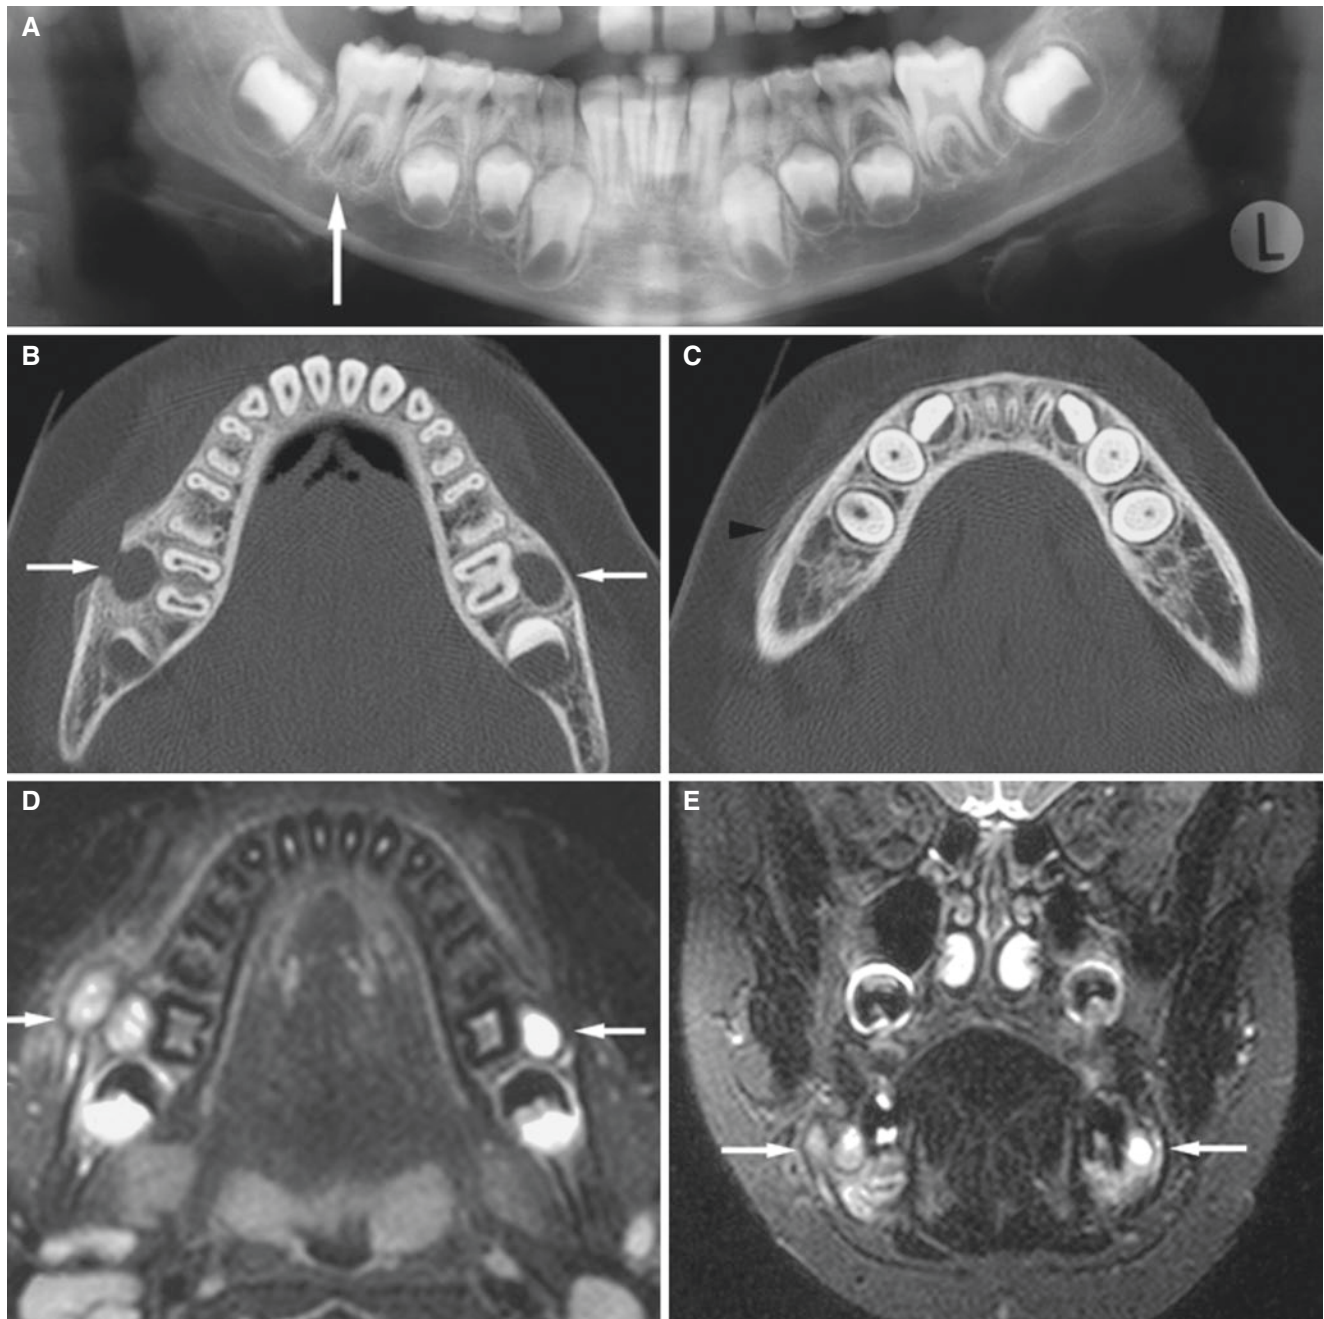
Paradental cyst, bilateral, mandible; 8-year-old male with right perimandibular swelling and pain. (A) Panoramic view suggests small radiolucency in root area of first molar (*arrow*). (B) Axial CT image shows buccal oval bone cavities bilaterally at first molars (*arrows*), with sclerotic outline on left side and with cortical defect on more severely inflamed right side. (C) Axial CT image shows periosteal
